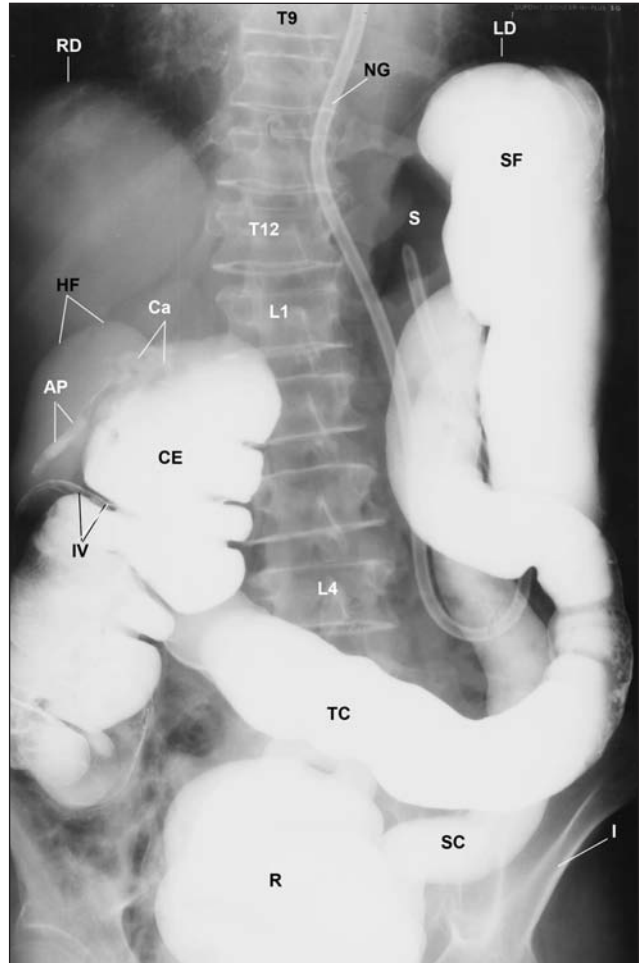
This is an anteroposterior radiograph of the abdomen after a barium enema. The images display the dilated splenic flexure (SF) of the colon, counter-clockwise rotation of the cecum (CE) into the left upper quadrant, the ileocecal valve (IV) lateral instead of medial to the cecum, and the left concave scoliosis of the thoracolumbar spine (T9-L4). The barium-filled appendix (AP) overlays the hazy density of the hepatic flexure of the colon. Ca = calcifications; HF = hepatic flexure of the colon; I = iliac bone; LD and RD = left and right hemidiaphragm; NG = nasogastric tube; R = rectum; S = stomach; SC = sigmoid colon; TC = transverse colon.
